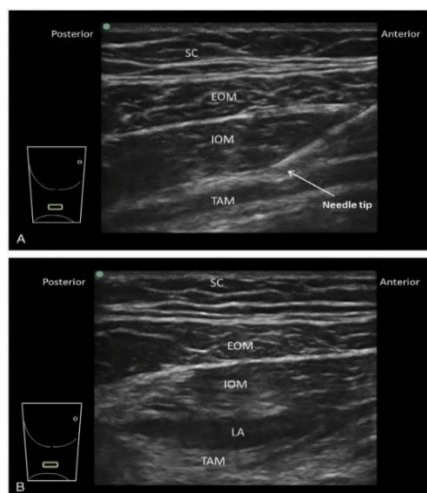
Ultrasound-guided transversus abdominis plane (TAP) block:(A): pre-injection image. (B): Post-injection image; local anesthetic (LA) has distended the TAP, separating internal oblique muscle (IOM) and transversus abdominis muscle (TAM) (20).
